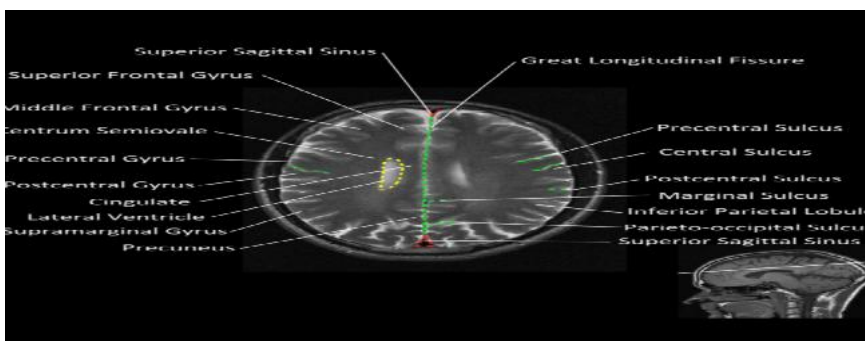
showing MRI brain - normal axial view of sub-cortical regions
